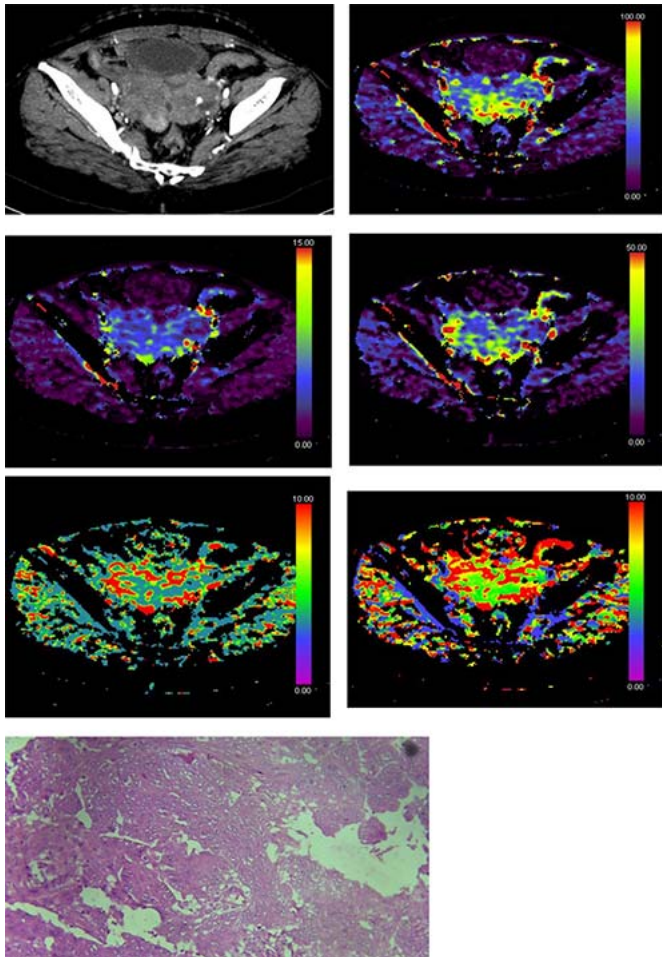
CT perfusion of bilateral high-grade serous cystadenocarcinoma a: PCT image showing bilateral solid vascular adnexal lesions b: BF right 97.84 and left 93.16 mL/100gm/min c: BV right 5.03 and left 4.98 mL/100gm d: FED right 27.74 and left 25.25 mL/100g/min. e: MTT right 3.09 and left 3.30-sec f: T max right 3.73 and left 5.31-sec g: HE 40x shows fused glands having pleomorphic nuclei with prominent nucleolus with focal areas of squamous differentiation.
